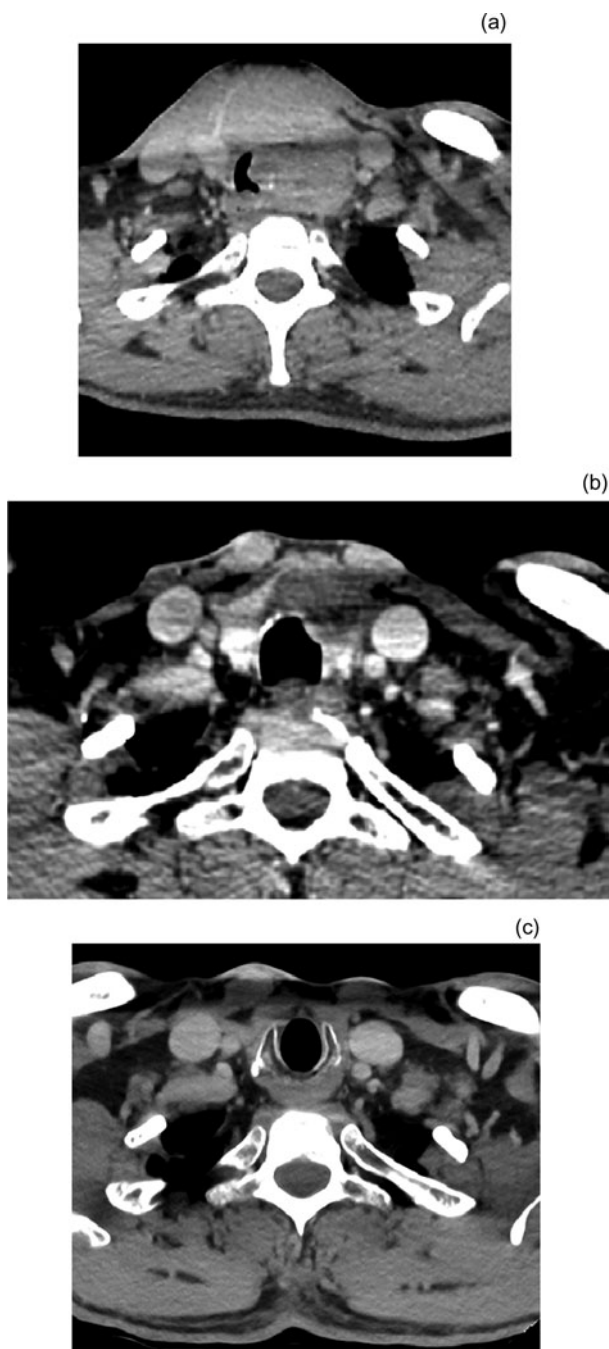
Case 2. Computed tomography showing: (a) axial plane image of left thyroid mass at presentation, (b) axial plane image showing 87 per cent tumour volume reduction after 17 months of tyrosine kinase inhibitors and (c) axial plane image with no evidence of local disease after 3 years.
